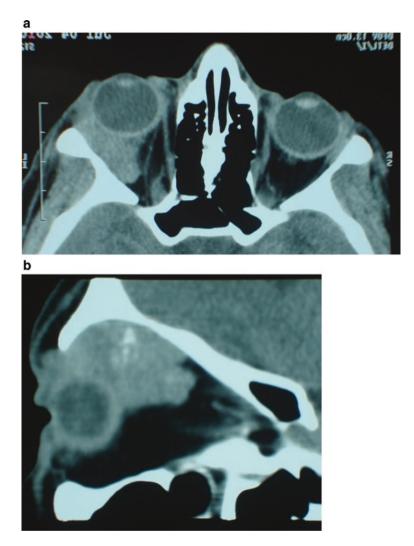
CT scan of a patient with ACC. Posterior irregular border of the tumor (a), and foci of calcifications (b) are visible
